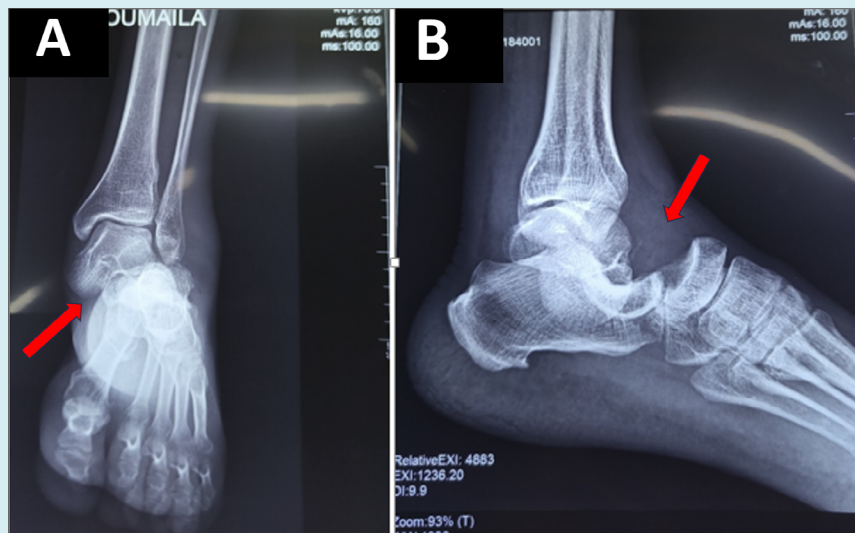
Standard radiographs of the left ankle, front (A) and side (B), showing the external subtalar dislocation (red arrows).
